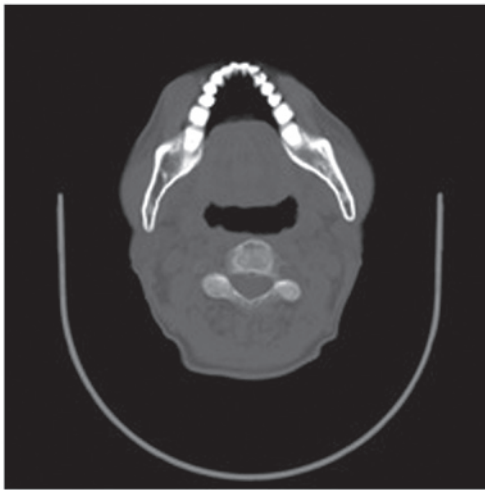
Computed tomography image demonstrating a soft-tissue mass measuring 2.8x2x1.4 cm in size, located in the buccal side of the right mandibular posterior gingiva.
